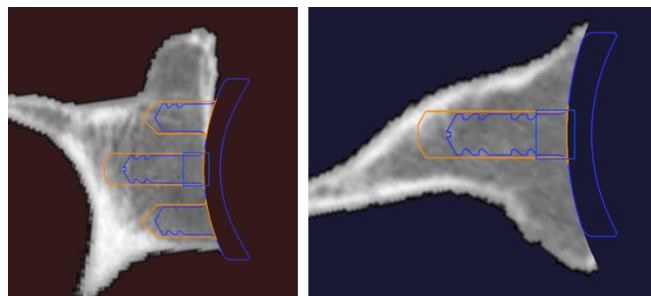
Preoperative Planning session is used to place the implant in 3D relative to the preoperative CT. Note that for a cemented glenoid the drilling depth for cement mantle is depicted relative to the glenoid vault.
